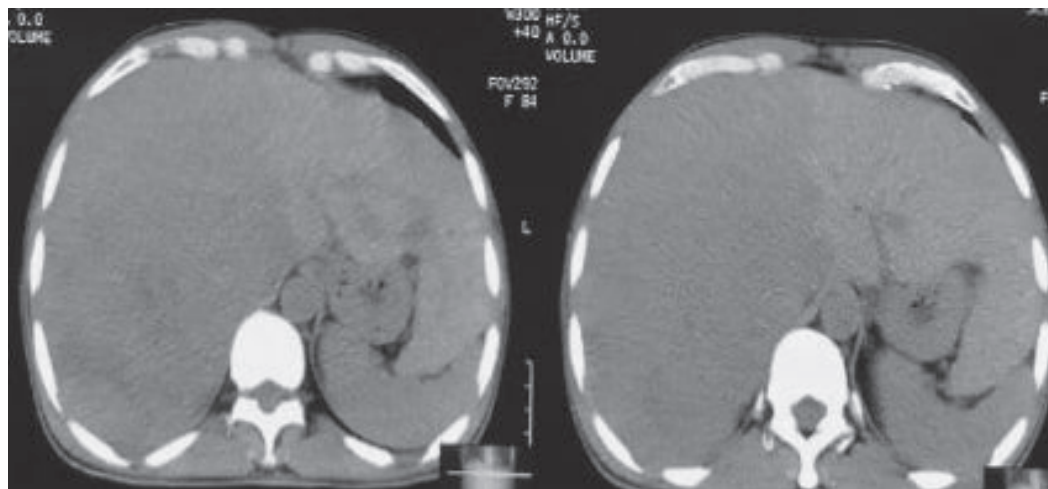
Axial pre-contrast CT scan of the abdomen in a 45-year-old male with HCC shows diffuse iso to hypodense lesions in the right lobe of the liver (Case 48)
